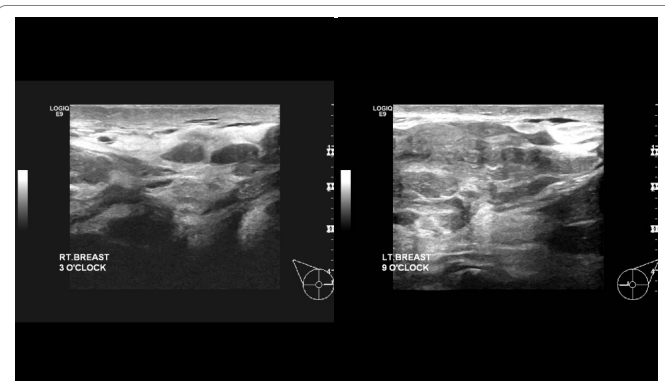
The breast ultrasound showed bilateral diffuse enlarged breasts with multiple variable sized hypos echoic masses seen scattered inside.
